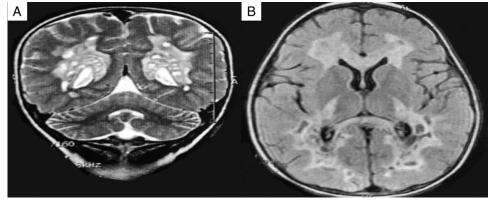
MRI (A) T2 and (B) T1 displaying diffuse leukodystrophy.
